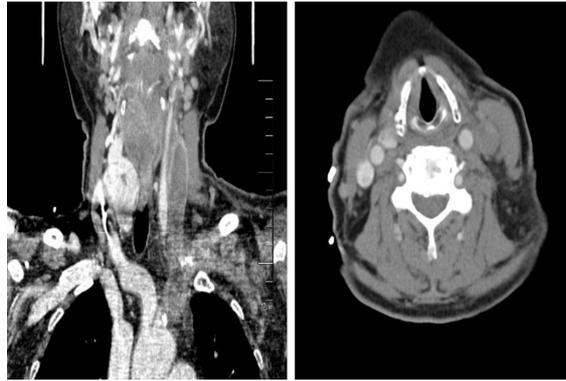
Computed tomography venography showed occlusion of the left common jugular vein, internal and external jugular veins, and subclavian vein.
